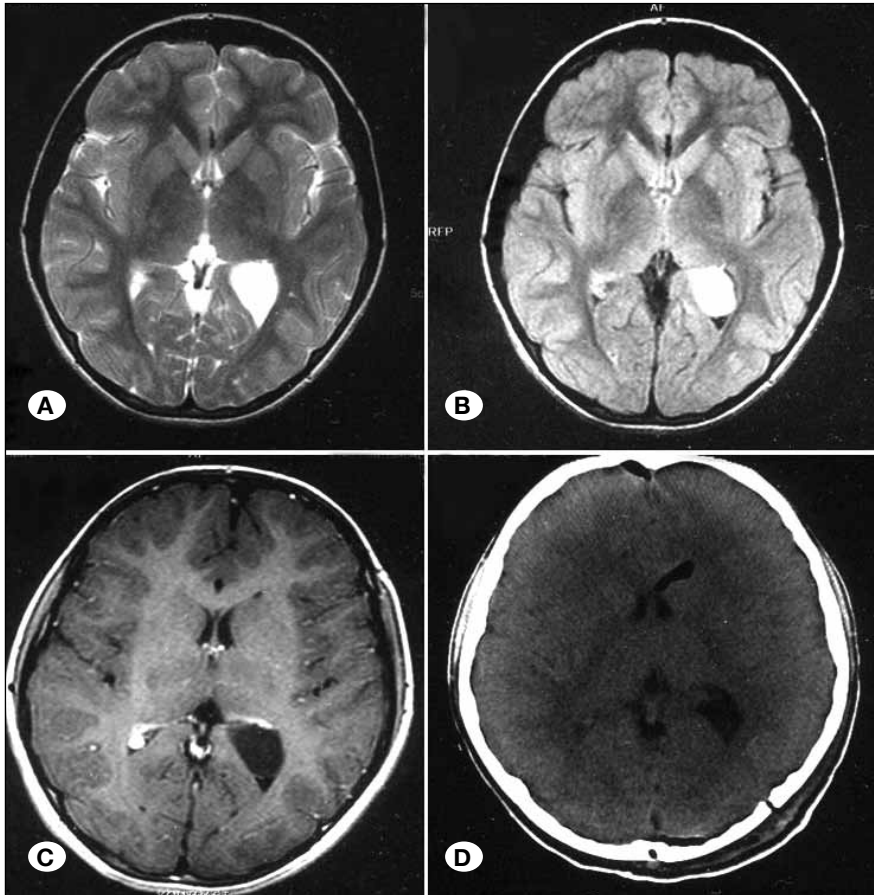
The T1-weighted MR images showed a round hypointense mass with a regular margin which was hyperintense in T2-weighted images in the left trigone of the lateral ventricle (A,B,C). CT scan, taken 1 day after the operation, revealed the total resection of the cyst and some postoperative changes (D). The diagnosis was benign epithelial cyst.
